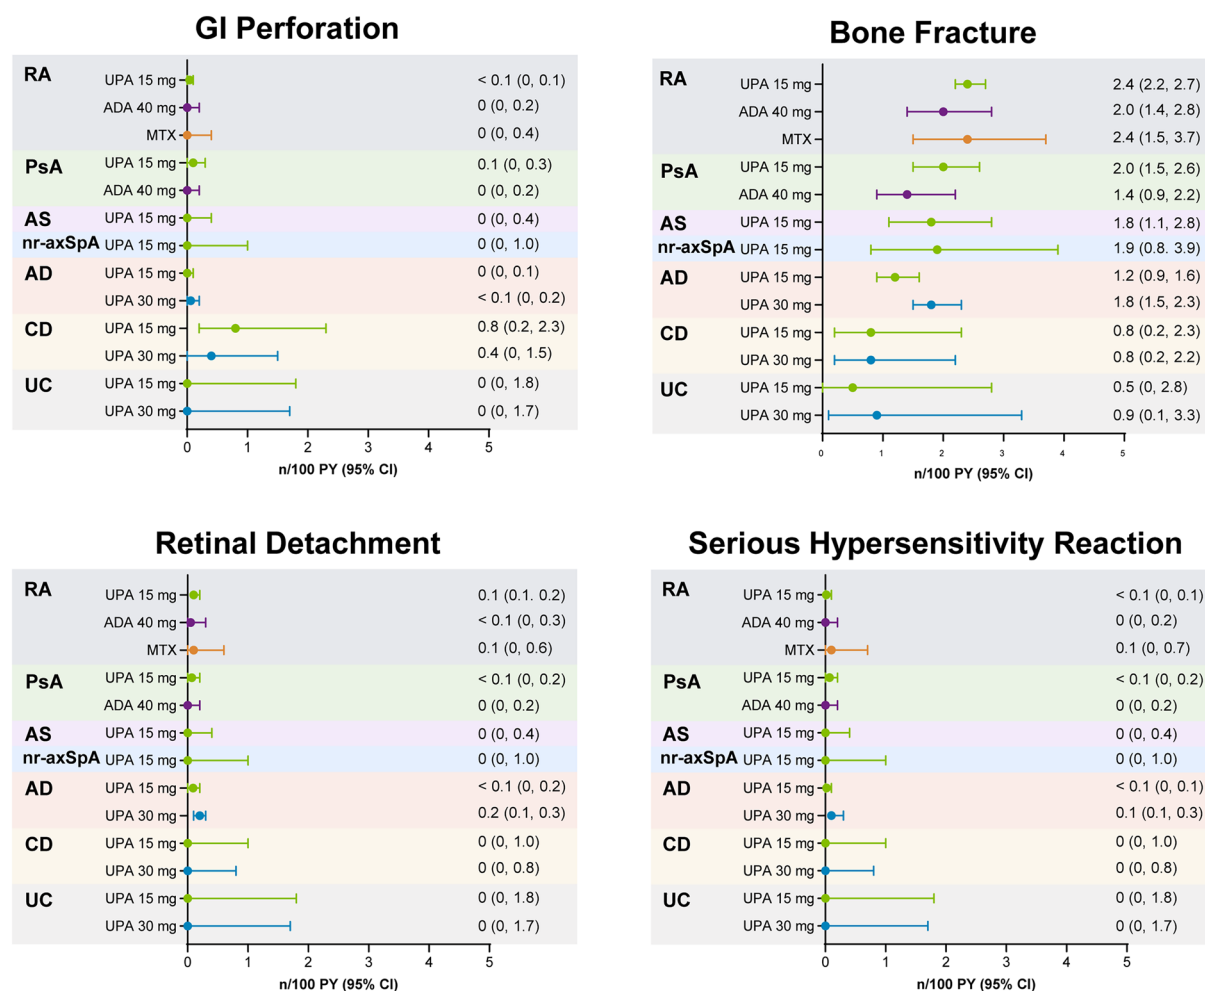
Exposure-adjusted incidence rates of GI perforation, bone fracture, retinal detachment, and serious hypersensitivity reaction^a. *AD* atopic dermatitis, *ADA* adalimumab, *AS* ankylosing spondylitis, *CD* Crohn's disease, *CI* confidence interval, *GI* gastrointestinal, *MTX* methotrexate, *n/100 PY* number of patients with at least 1 event per 100 patient-years, *nr-axSpA* non-radiographic axial spondyloarthritis, *PsA* psoriatic arthritis, *RA* rheumatoid arthritis
